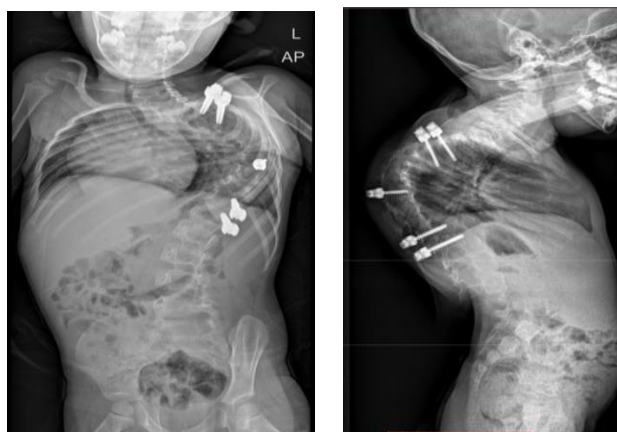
Standing AP and lateral radiographs obtained after posterior vertebral tethering and before HPT, demonstrating progression of the rigid thoracolumbar kyphoscoliosis and tether failure.
